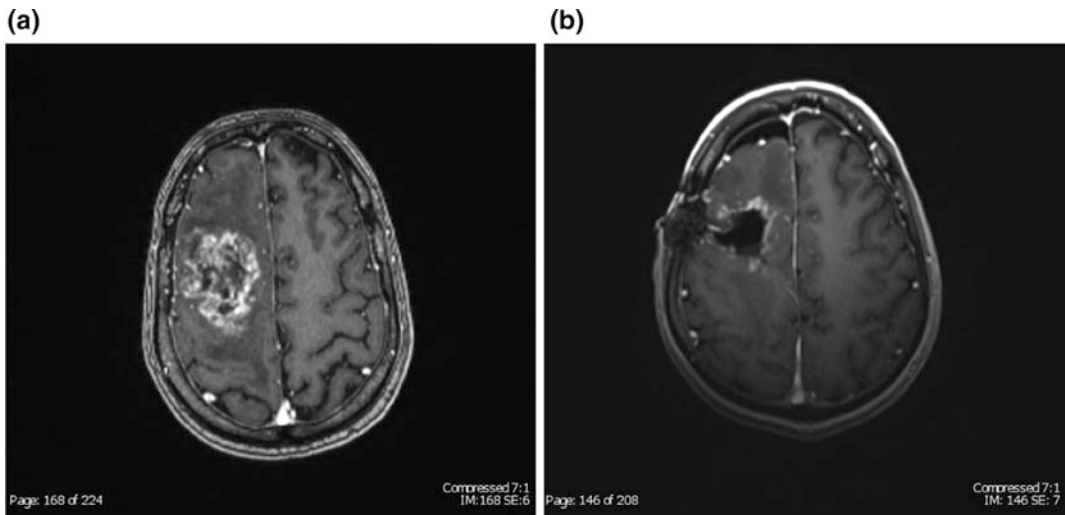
A 47-year-old man with recurrent GBM after treatment with radiation and chemotherapy. Preoperative T1-weighted post gadolinium MRI (a) reveals a right frontoparietal mass. Intraoperative T1-weighted post
